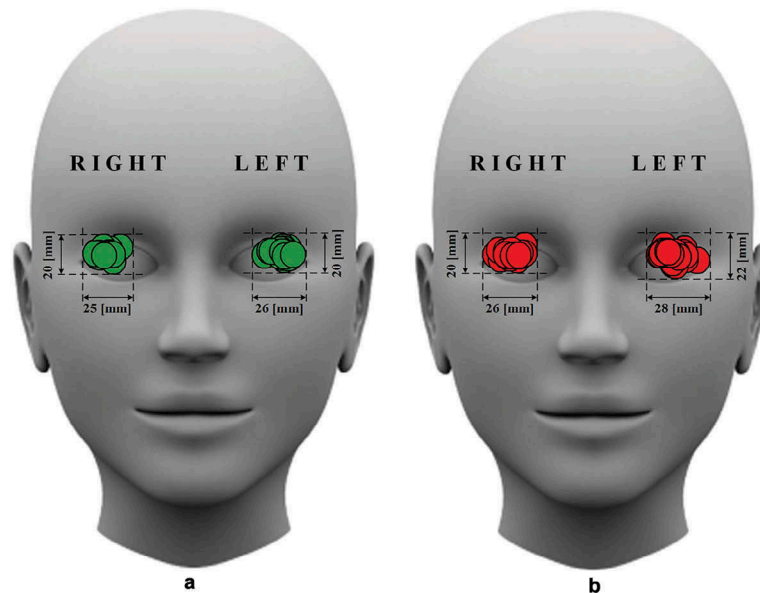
Relative positions of the ultrasonic transducer (UT) on the closed eyelid in the case of the located (a) intracranial segment of the ophthalmic artery simultaneously selected with the extracranial segment of the ophthalmic artery and (b) edge of the internal carotid artery. The width and height of the window within which the UT surface falls are indicated in millimetres.
